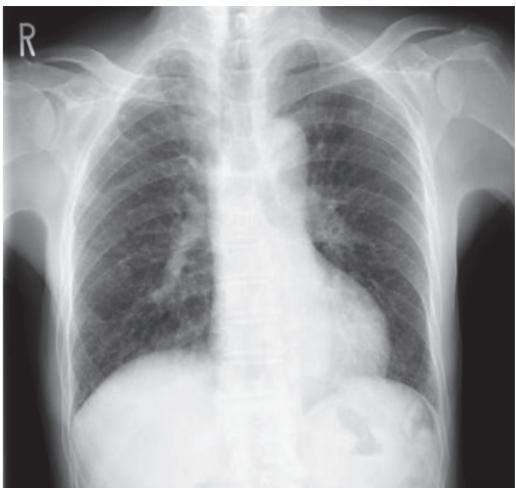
The chest X-ray and CT findings 6 months after hormonal therapy. The PSA level was 0.521 ng/mL.
